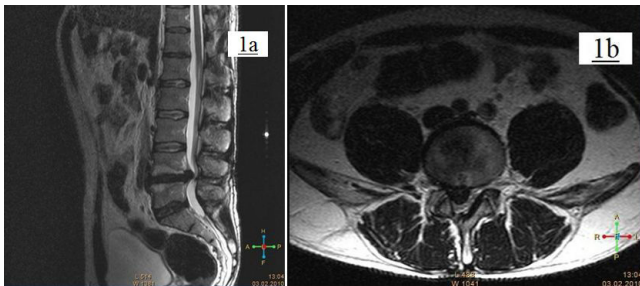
On first admission of the patient, preoperative MR scans (A-B) demonstrated disc herniation at L4-5 level. T2-weighted images revealed a disc fragment that hugely extruded toward to central spinal channel
